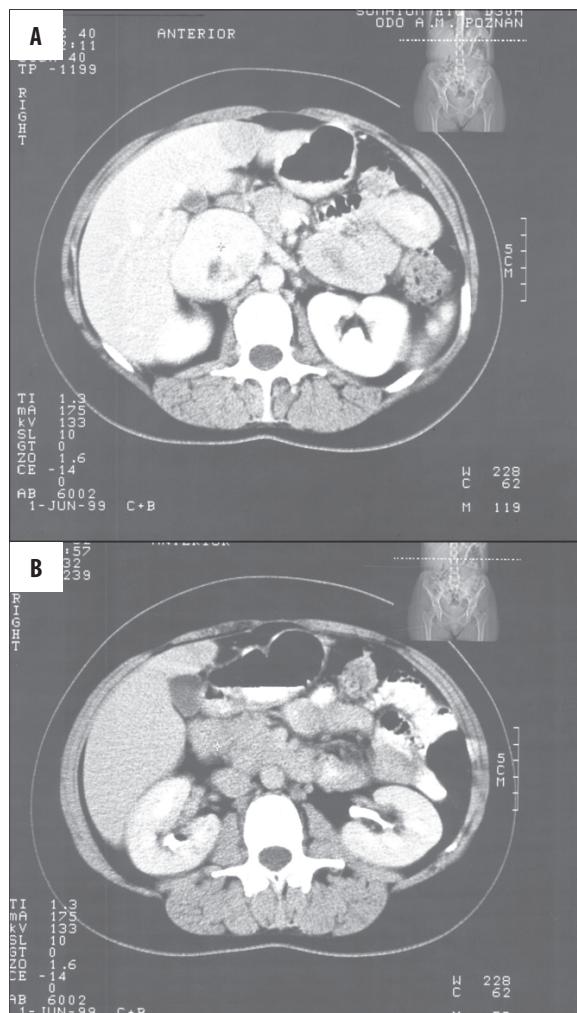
Contrast enhanced CT. (A) Intensive enhancement of tumor masses accompanied by thrombosis in vena cava inferior (tumor masses and thrombus inside the lumen). (B) Both kidneys without visible pathology.
